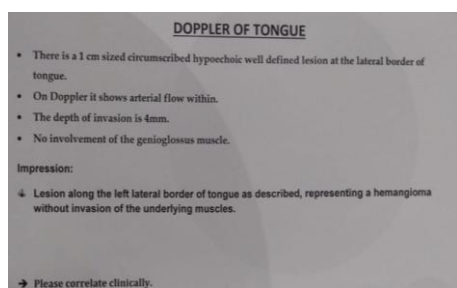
Colour Doppler report
